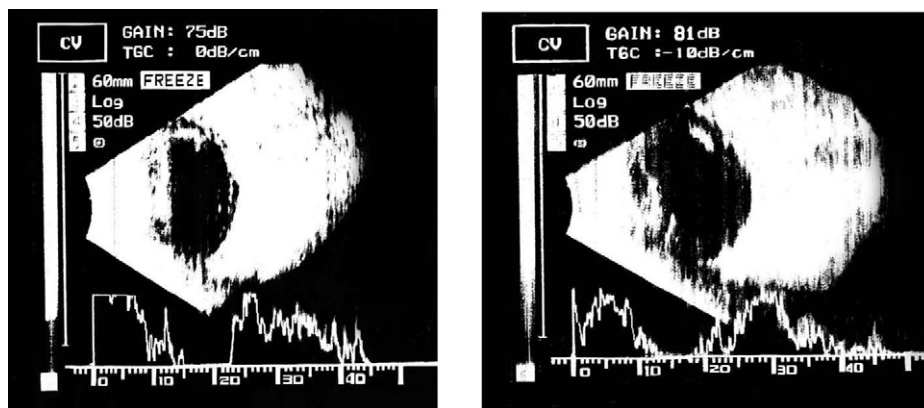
Ultrasound of the left eye of the patient.
